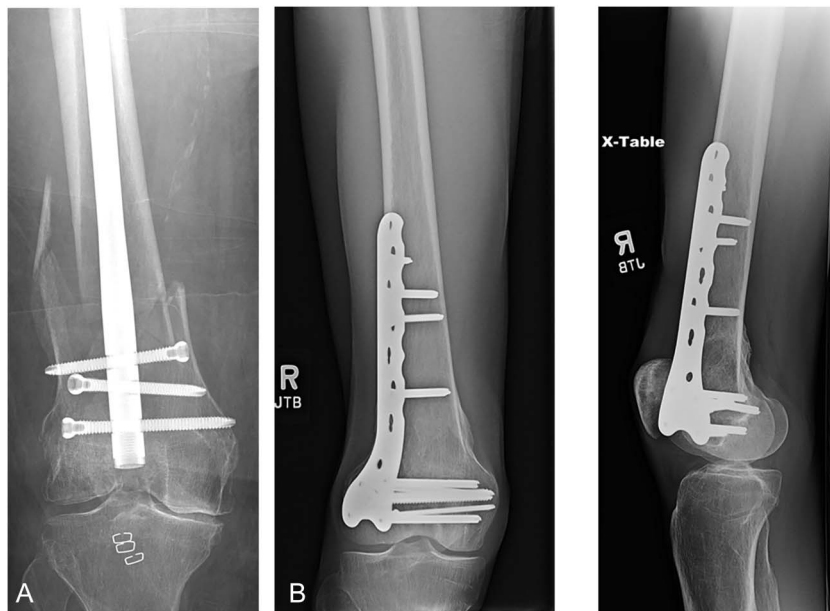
A, Anteroposterior radiograph of fracture fixed with intramedullary nail. B, Anteroposterior radiograph of fracture fixed with lateral locked plate and screw construct with union.
